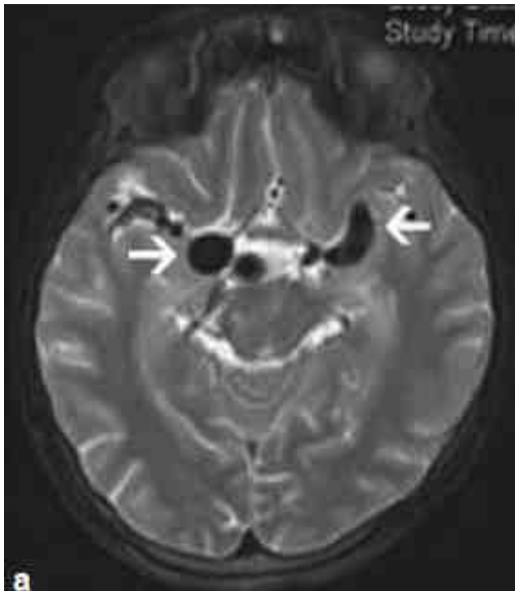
MRI- Internal carotid artery aneurysm
